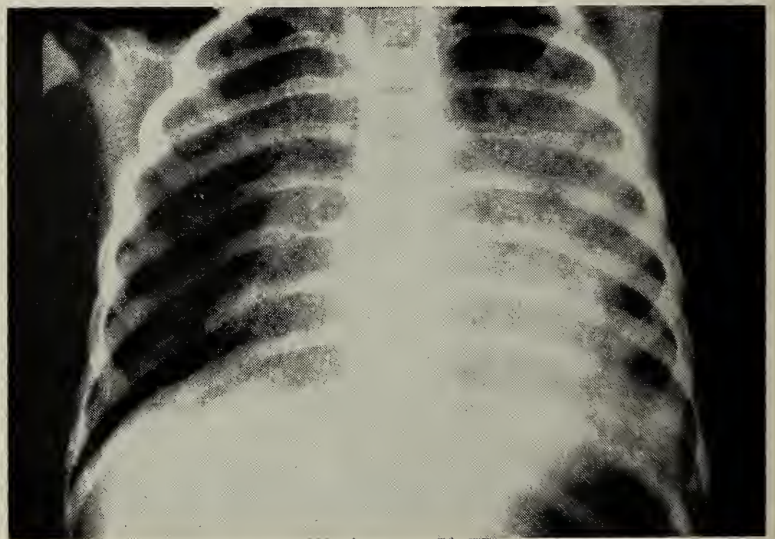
Chest roentgenogram reveals a bilateral perihilar infiltrate. There is no evidence of fluid or other abnormality.
